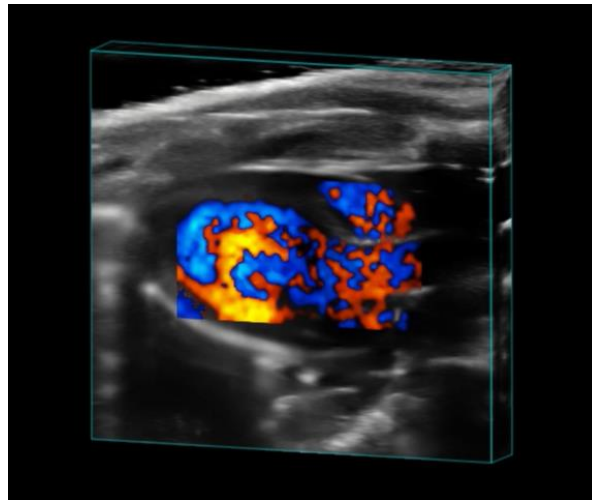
4D Color image of heart (4D Color is not available on Vevo ultrasound systems released before the Vevo F2)
